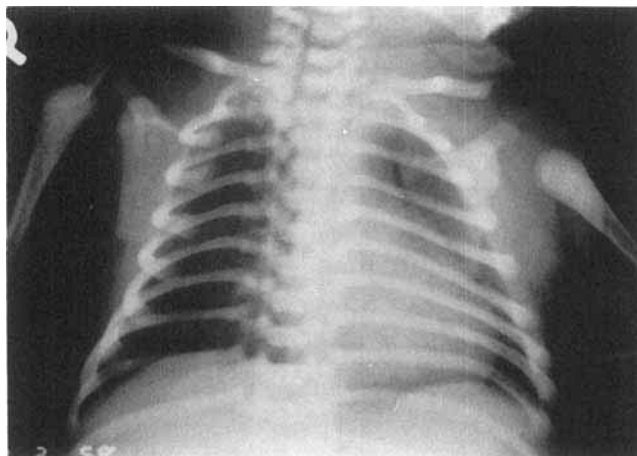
Case 6: radiograph of thorax showing asymmetry of the thoracic cage due to aplasia of the right pectoralis major and the minor muscles.
